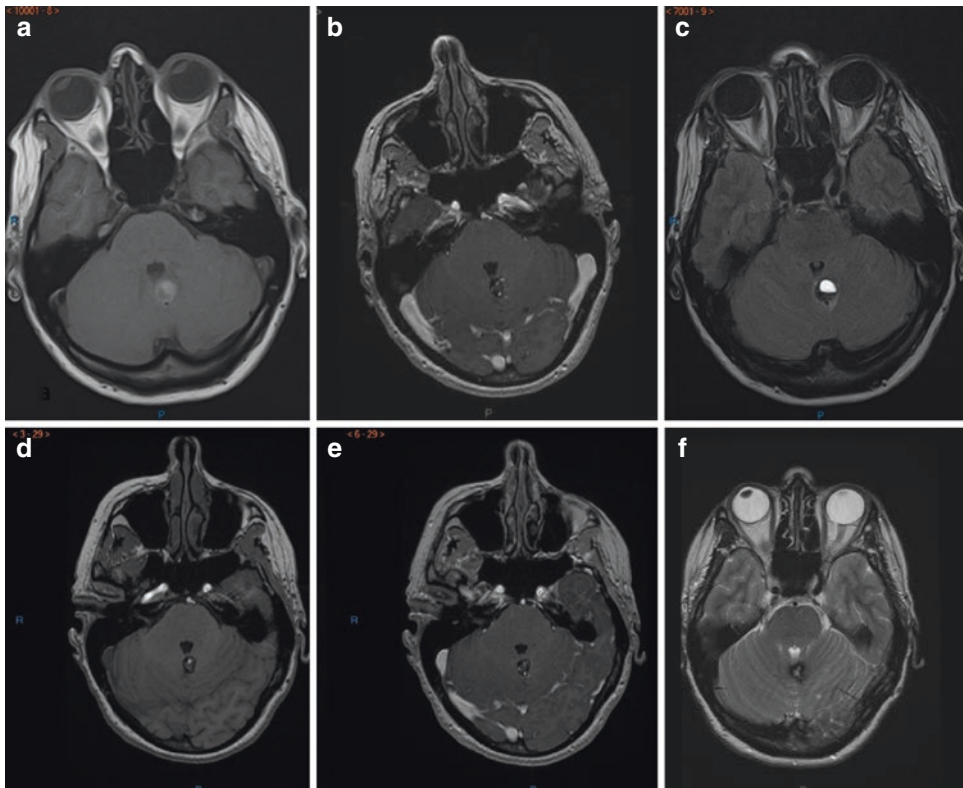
Cerebellar cavernoma that bled 3 times in 3 years. MRI before treatment (at third hemorrhage) (a–c) and 1 year after treatment (CyberKnife radiosurgery) (d–f). No parenchymal changes were visible, and cavernoma image remained unchanged. No hemorrhage and no radio-induced changes
